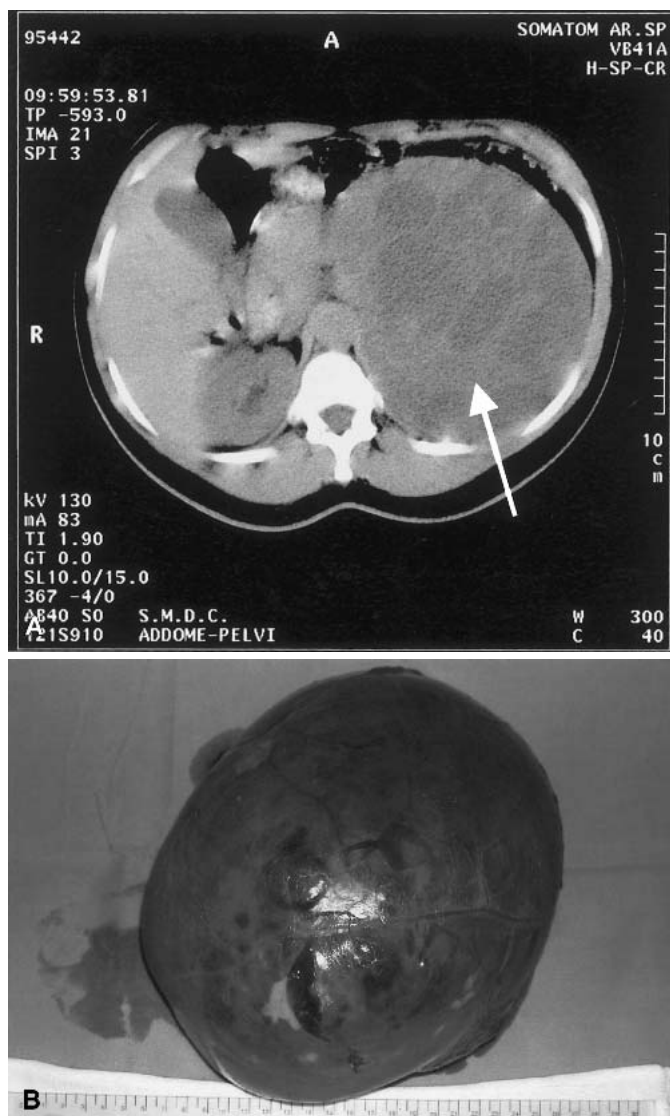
Abdominal CT scan in patient no. 13, showing a large carcinoma of the left adrenal gland (size, 15 cm), dislocating laterally gut, and causing lateral and inferior dislocation of the liver to the opposite site of the abdomen. A very inhomogeneous pattern is evident even without contrast (A); tumor appearance after complete surgical removal; it is well capsulated, sized 20 cm (B).
